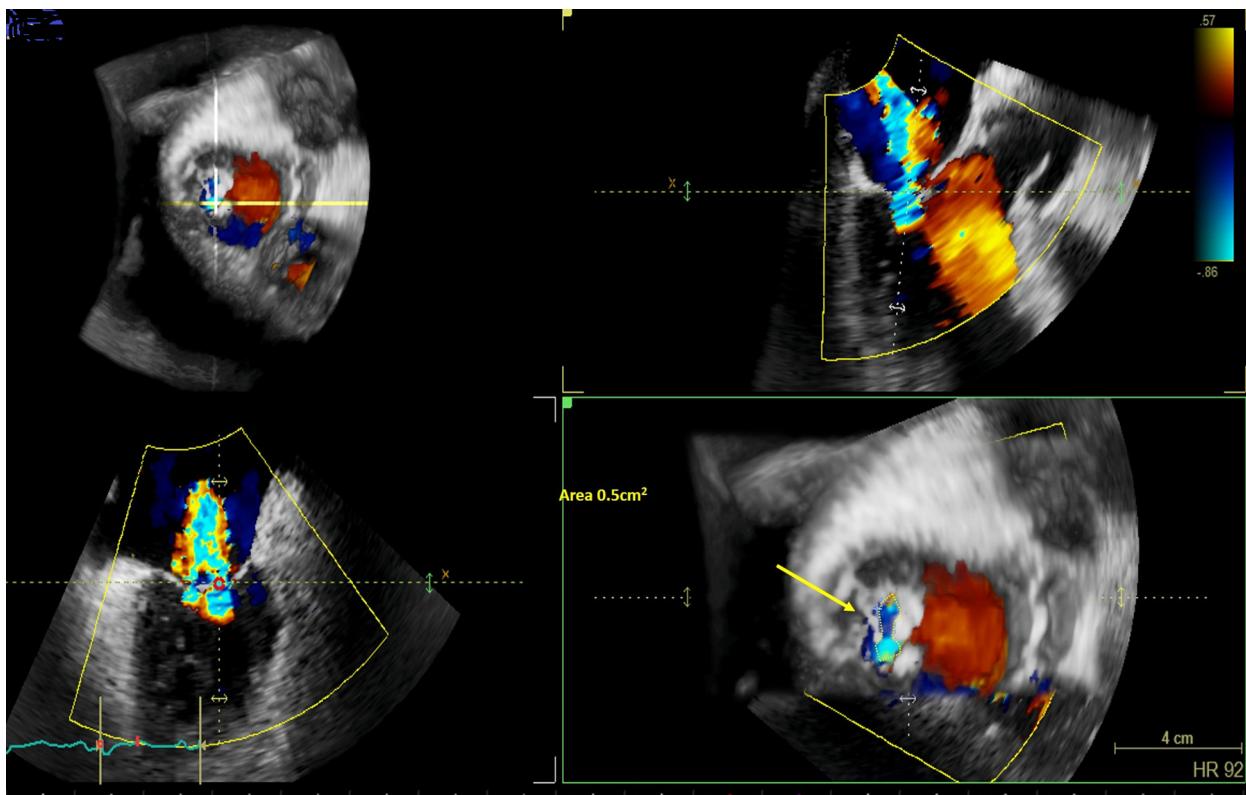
Vena contracta area by 3D TEE multiplanar analysis with color Doppler. Note that optimally oriented cut planes provide an en-face view of the vena contracta region. The regurgitant orifice has an irregular shape (right lower panel) that can be directly planimetered (arrow) with the use of 3D echocardiography.
